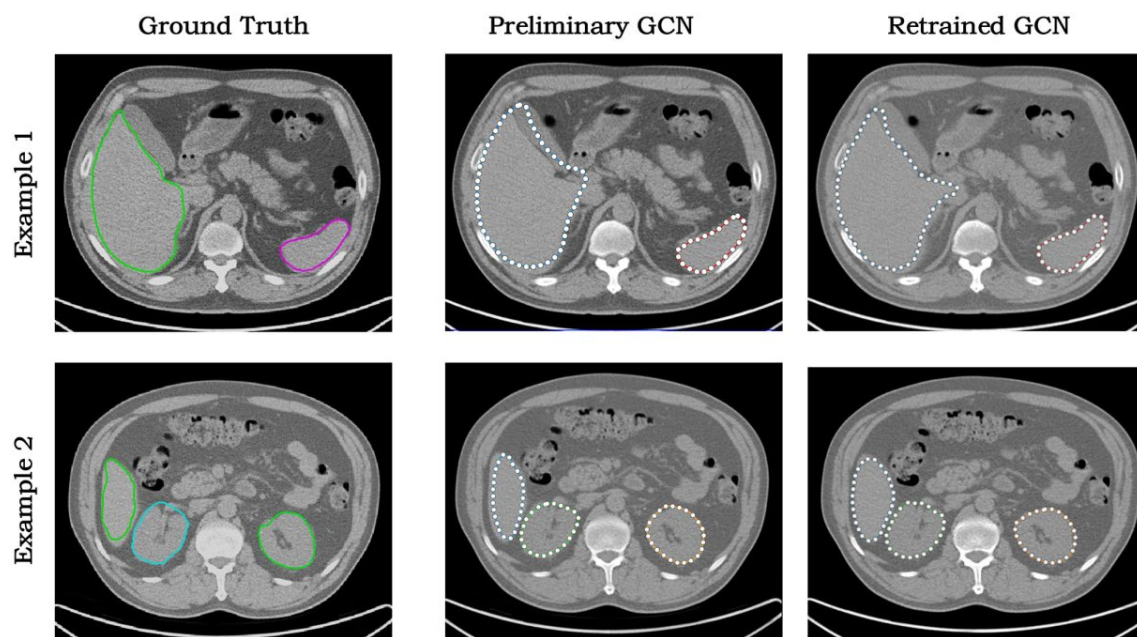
AID annotation results of two exemplar CT slices
